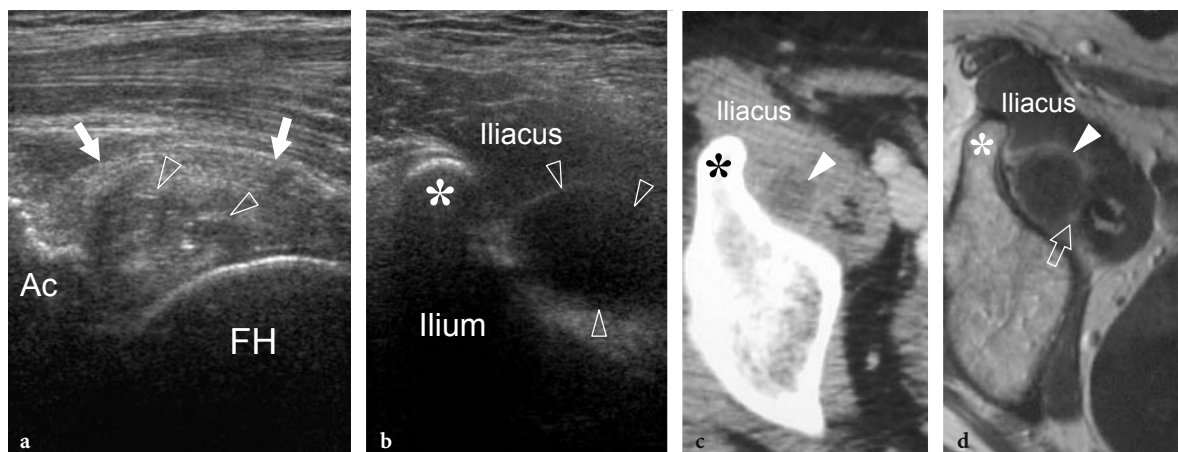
Anterior ganglion cyst in a patient with chronic hip pain and symptoms related to femoral neuropathy. a Sagittal 12–5 MHz US image obtained over the femoral head (FH) and b transverse 12–5 MHz US image obtained over the anterior inferior iliac spine (*asterisk*) reveals the ganglion cyst (*arrowheads*) arising from a degenerated and heterogeneous anterosuperior labrum (*arrows*) and expanding between the deep boundary of the iliacus muscle and the anterior aspect of the ilium. At this level, the ganglion appears as an anechoic cystic structure. Ac, acetabulum. c,d Transverse c CT scan and d Gd-enhanced T1-weighted MR image obtained at the same level as b confirm the US findings. In d, observe a rim of contrast enhancement (*arrow*) depicting the cystic wall. In this particular case, the mass effect of the ganglion cyst led to an indirect compression of the femoral nerve which courses under the fascia of the iliacus muscle. Surgical removal of the ganglion caused relief of the symptoms
